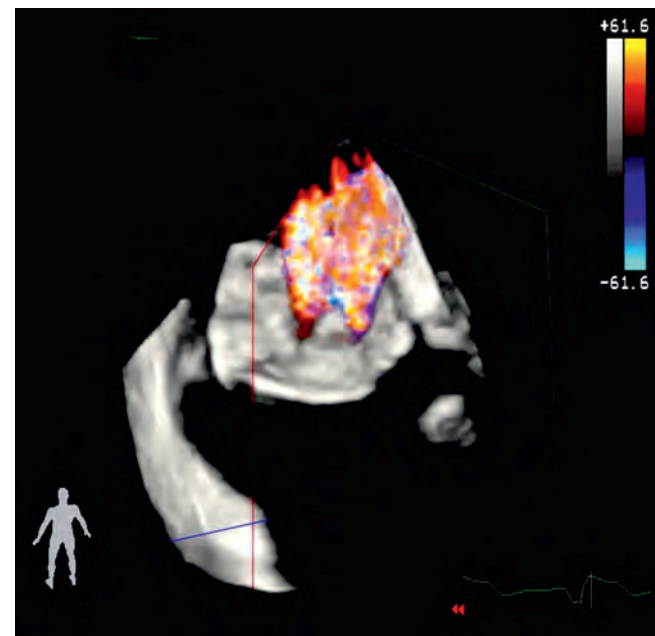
Three-dimensional color-flow Doppler assessment of the mitral valve demonstrates a large regurgitation jet originating within the central two-thirds of the line of coaptation.
